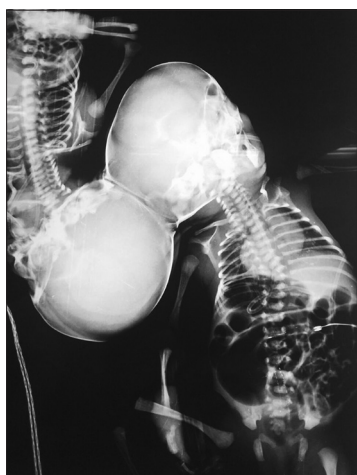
X-ray of craniopagus twins
